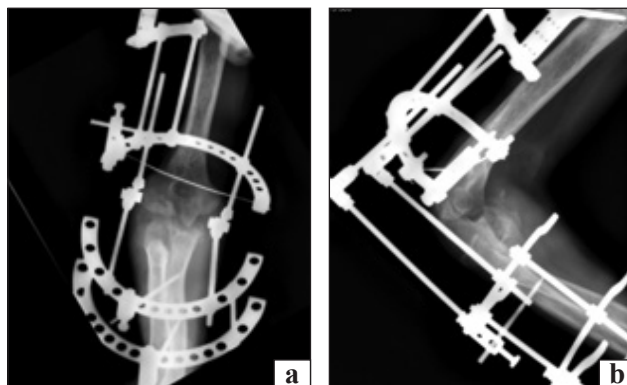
Radiographs in direct (a) and lateral (b) projections after completion of the stage of hardware reduction of the forearm
